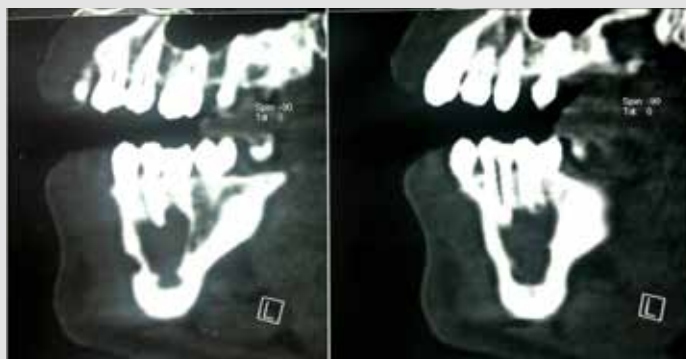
Sagittal CT showing soft tissue lytic lesion in the right posterior mandible
